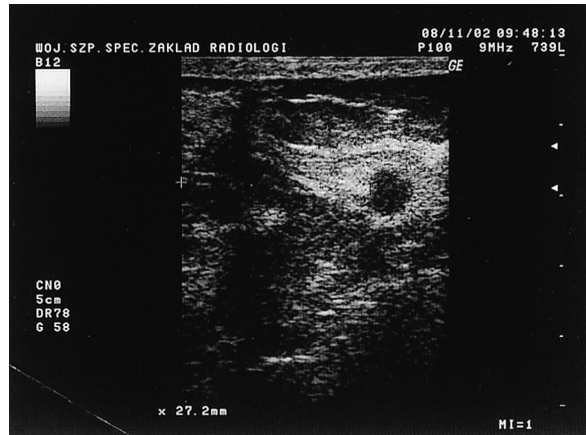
Patient's ultrasonography.
